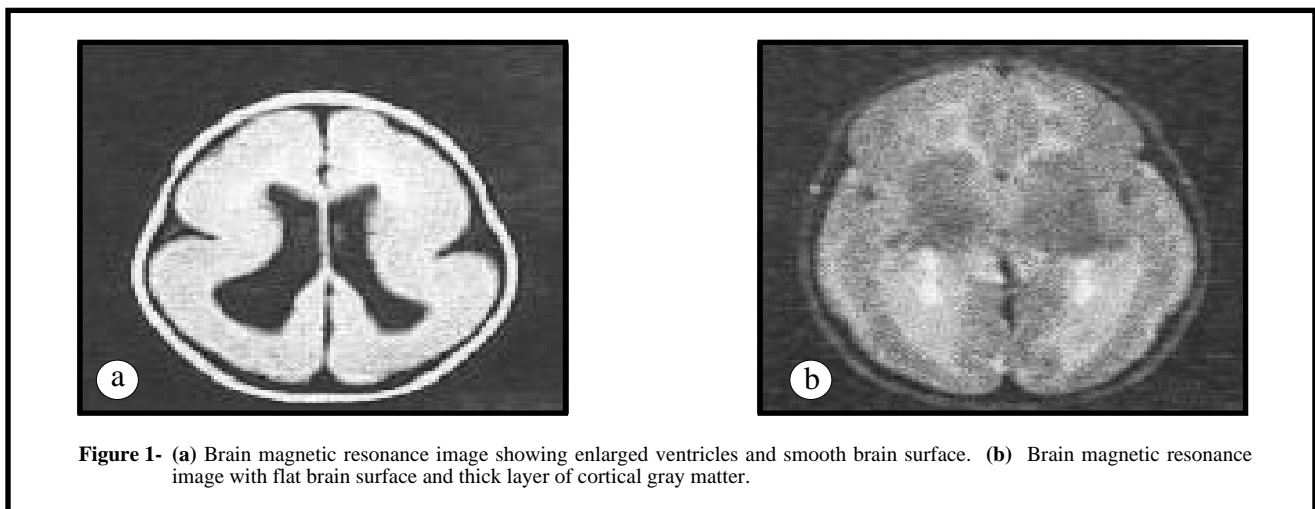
(a) Brain magnetic resonance image showing enlarged ventricles and smooth brain surface. (b) Brain magnetic resonance image with flat brain surface and thick layer of cortical gray matter.
